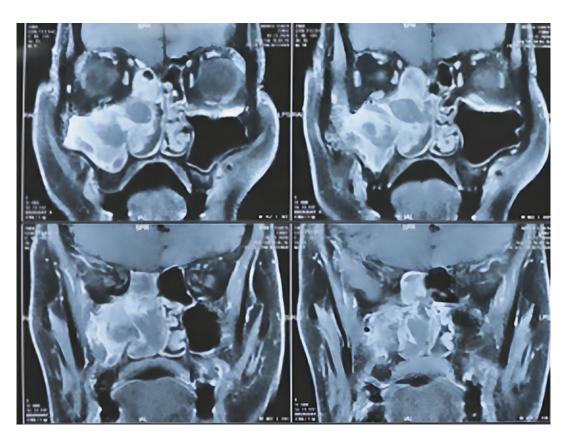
MRI scan: a coronal plane showing a lesion involving the right medial wall of the maxilla and the lesion extending into the right maxillary, right anterior ethmoid and right nasal cavity
